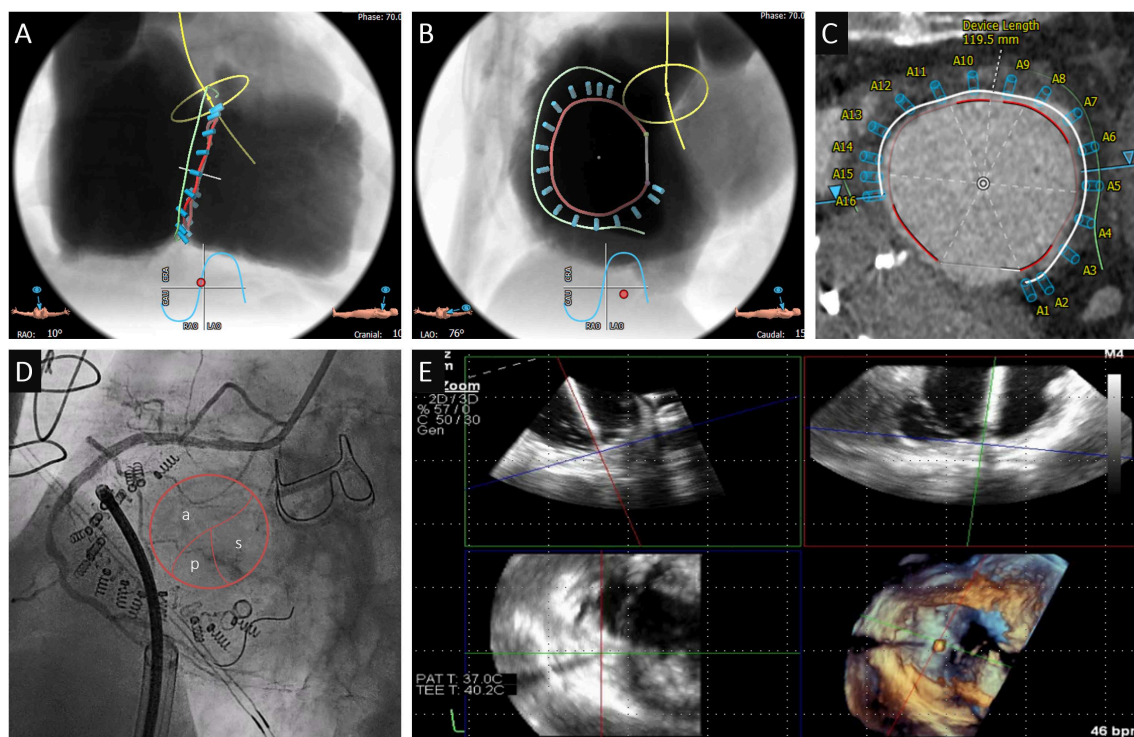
Annuloplasty case. (A–C) Preprocedural MSCT planning of the Cardioband implantation (projection A: RAO 10—CRAN 10; B: LAO 76—CAU 15; green line: reconstruction of the RCA). (A,B) Anticipated localization of the screws in relationship with the RCA. (C) Measurements of the distance between annulus and RCA. (D) Angiography of the RCA after Cardioband cinching (projection: LAO 52—CAU 10) with “en face” view of the TV. The ostium and proximal part of the RCA are in close proximity to anterior leaflet while the periphery is close to the posterior leaflet. (E) MultiView echocardiography for intra-procedural guiding of screw implantation allowing catheter localization in three planes.
